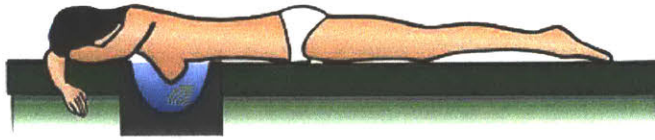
Ring array UST systems and images with comparison to MRI
